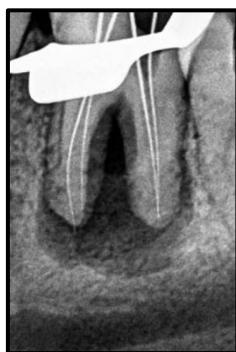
b: Working length radiograph
